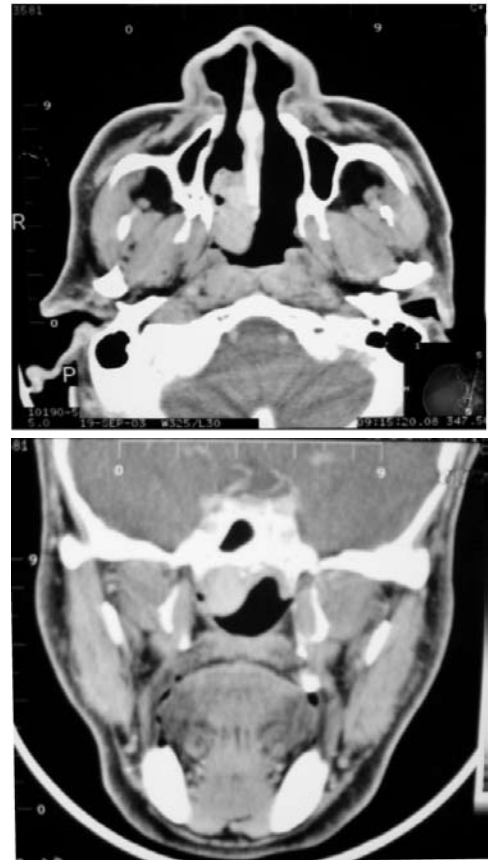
Computed Tomography, axial and coronal sections, showing mass arising from the right postnasal space extending inferiorly to the oropharynx without any bony involvement.
